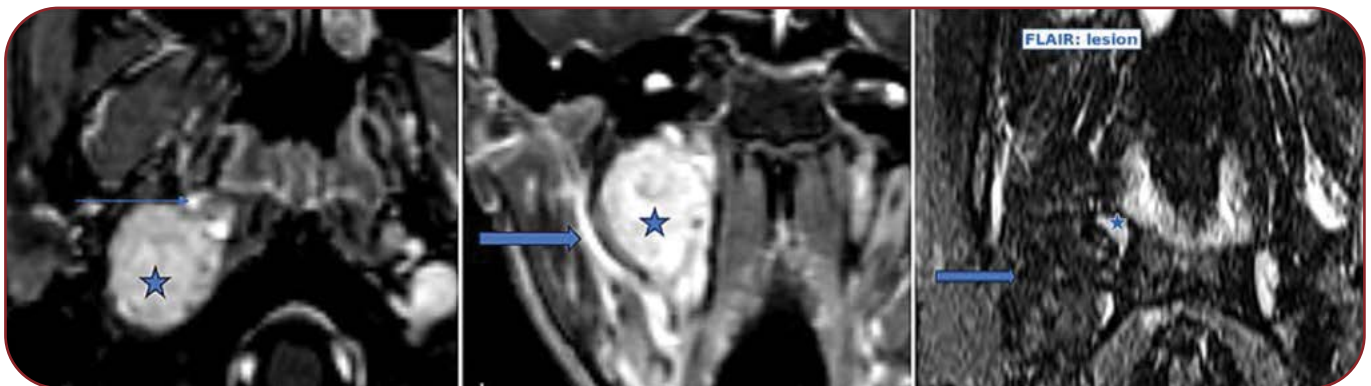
Case 4: vagal paraganglioma. Contrast-enhanced magnetic resonance imaging (CEMRI) axial and coronal images of the skull base revealed a well-defined lobulated mass lesion (star) epicentered just inferior to the right jugular fossa. The lesion shows intense homogeneous enhancement on post-contrast images. It displaces the internal carotid artery (thin arrow) anteromedially and the internal jugular vein (thick closed arrow) posterolaterally, without widening of the carotid bifurcation. The T2-weighted/FLAIR image demonstrates heterogeneous hyperintensity with internal flow voids (salt-and-pepper appearance). In the rightmost FLAIR image, the blue arrow and star indicate the same vagal paraganglioma. FLAIR=fluid-attenuated inversion recovery
